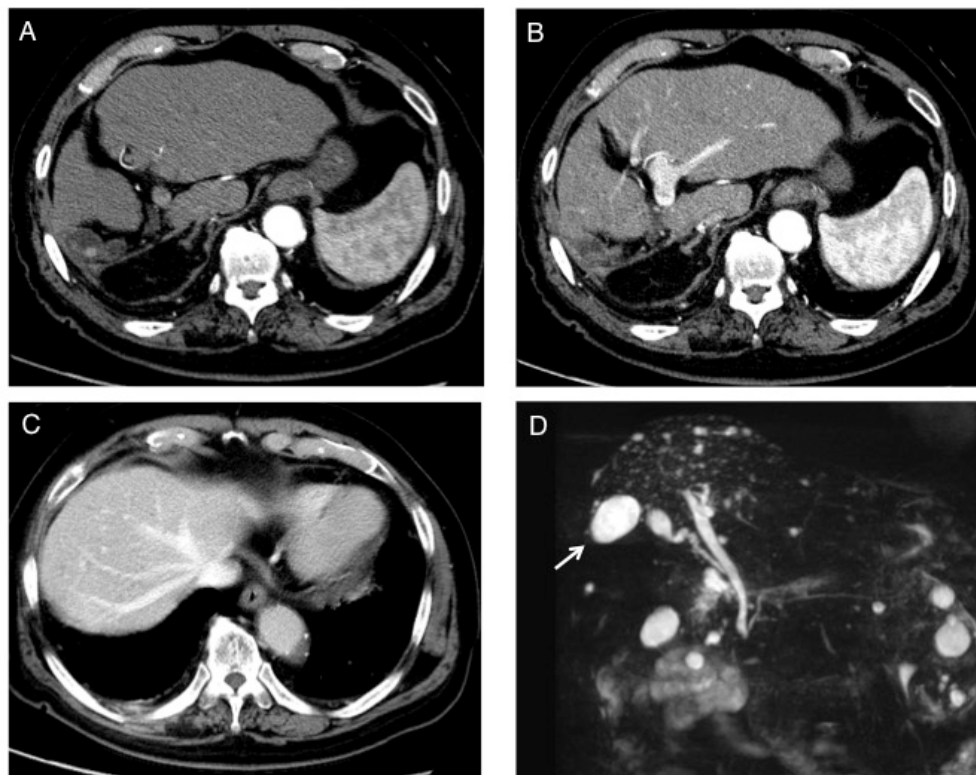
A-C Contrast-enhanced CT. (A) The gallbladder was located on the right dorsal side of the liver, which had no right lobe; (B) The right portal vein was not visualized; (C) There were several veins draining the medial side, but no right hepatic vein; (D) MRI cholangiography showed no right hepatic duct.
